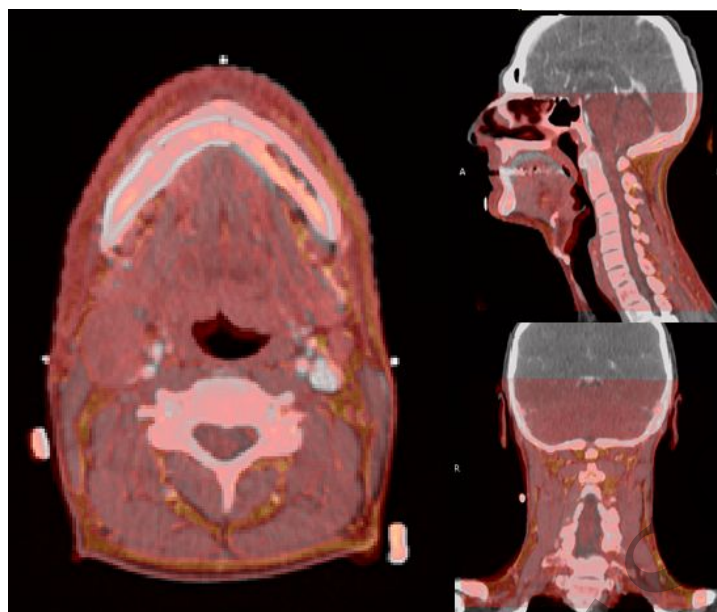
Global RIR for a patient with an oropharyngeal squamous cell carcinoma. Grey overlay images are CT and red overlay images are MRI.
